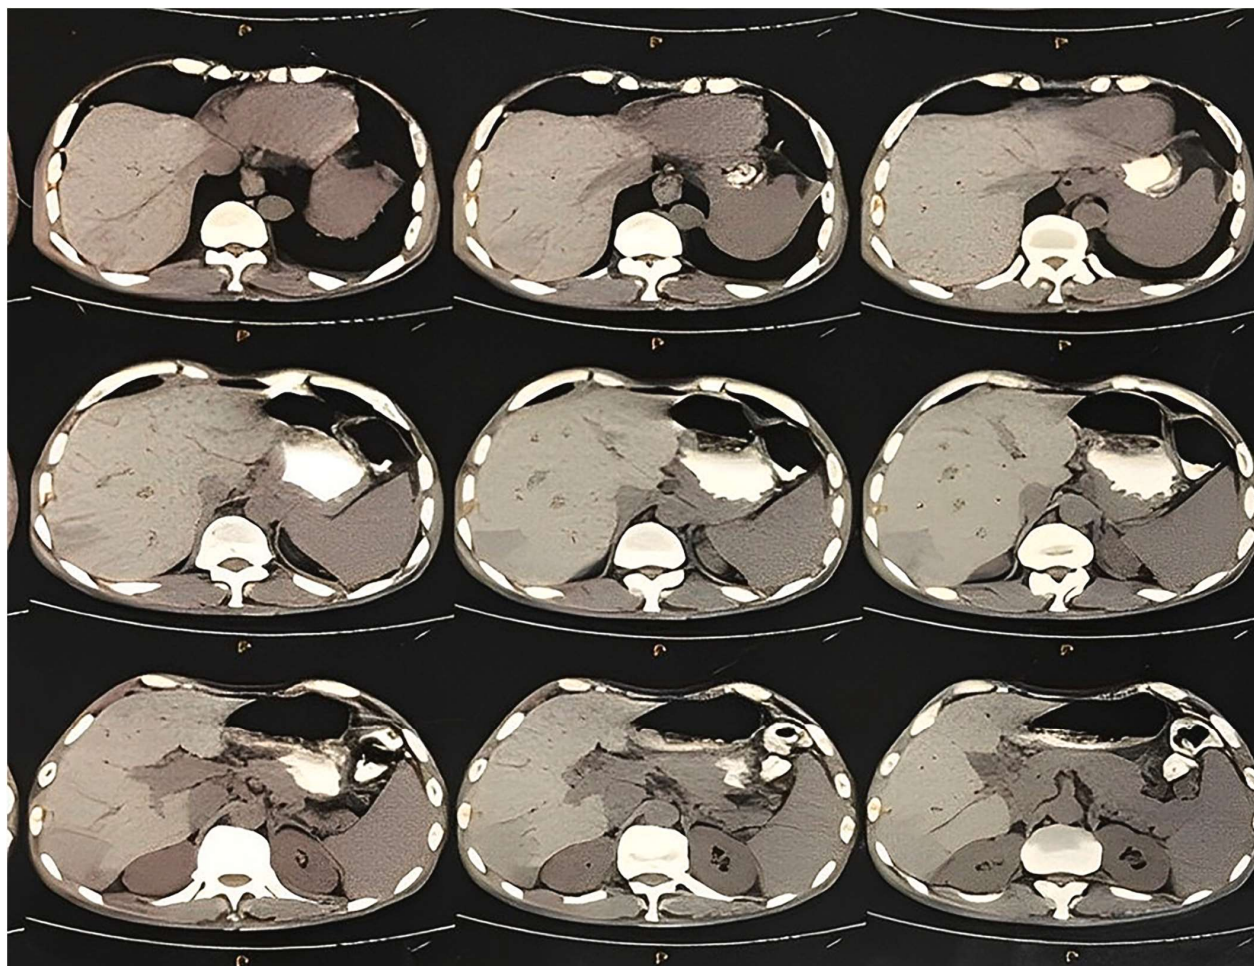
Abdominal computed tomography scan showed multiple peritoneal and liver tumors in patient with biopsy-proven actinomycosis.
